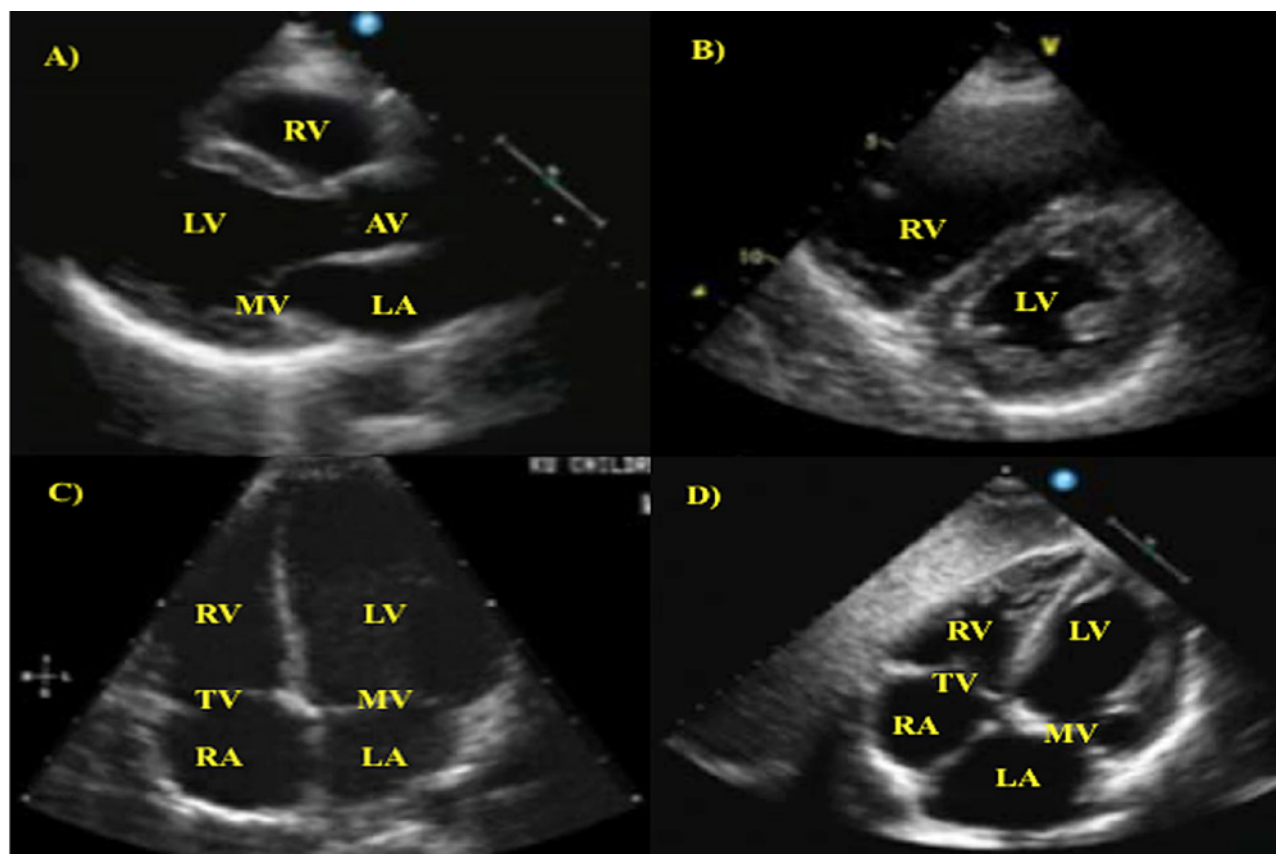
Transthoracic echocardiogram images from four cardiac views. A) parasternal long-axis view. B) parasternal short-axis view. C) apical four chamber view. D) subcostal four chamber view.
